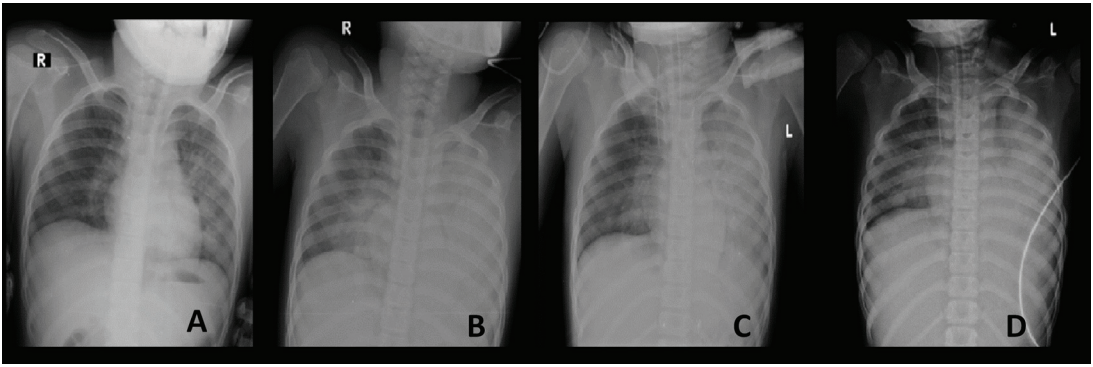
Chest radiograph of the patient (case 1). (A) In the first 24 hours after hospital admission. (B) Over the next 48 hours, portable chest radiograph showed haziness at total left lung and greater infiltration of the right lung. (C, D) After PICU admission, a high-setting mechanical ventilator was prescribed on the first and second day of PICU admission.
